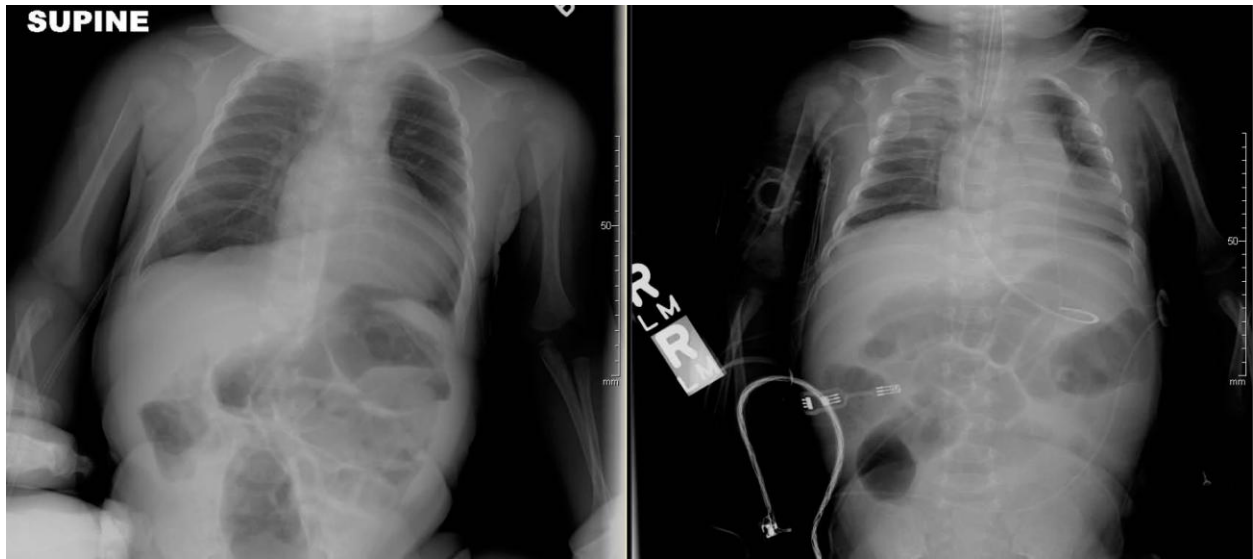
The left panel demonstrates a chest radiograph shortly after admission. No significant pathology is noted. The right panel demonstrates a chest radiograph from the fifth day of admission. Ground-glass opacifications are present in the right upper and left lower lobes.
